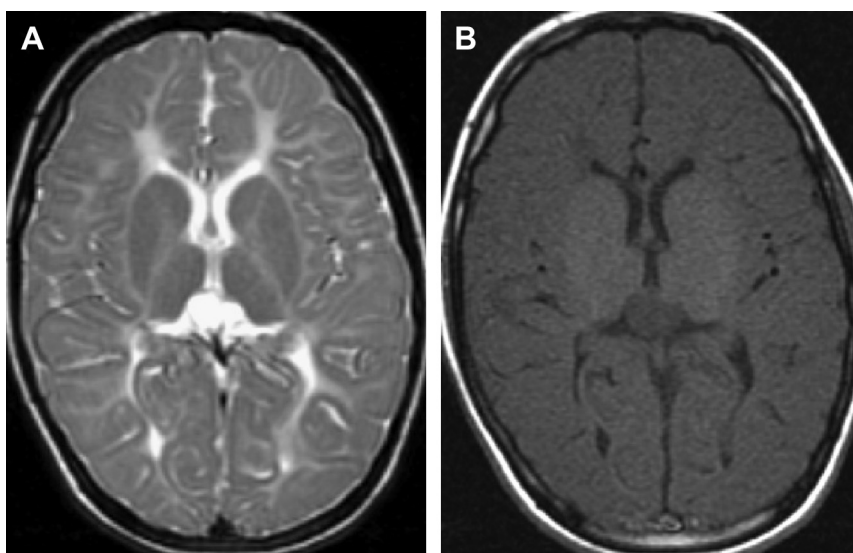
Seven-year-old girl with developmental delay and Salla disease diagnosed at 3 years of age. Axial T2-weighted (A) and T1-weighted (B) images demonstrate absence of normal myelination.
